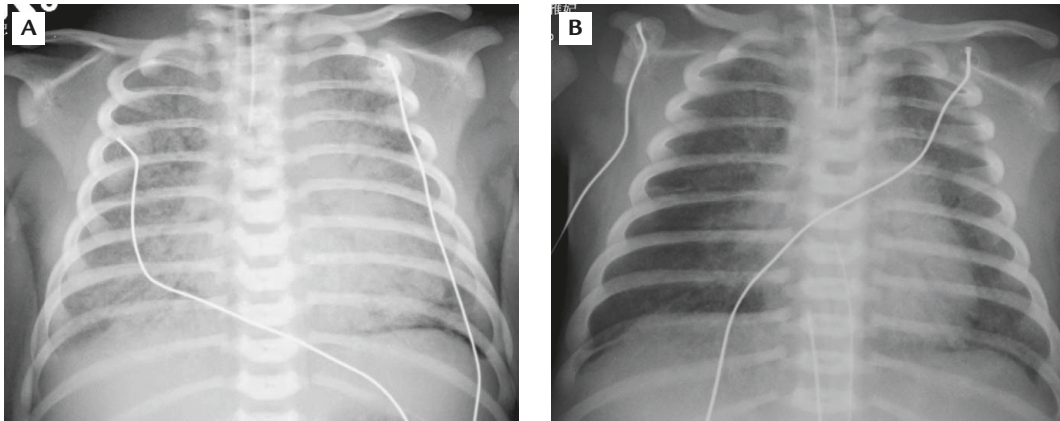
Chest X-ray of Case 1: (A) before lavage; (B) 24 hours after lavage.
